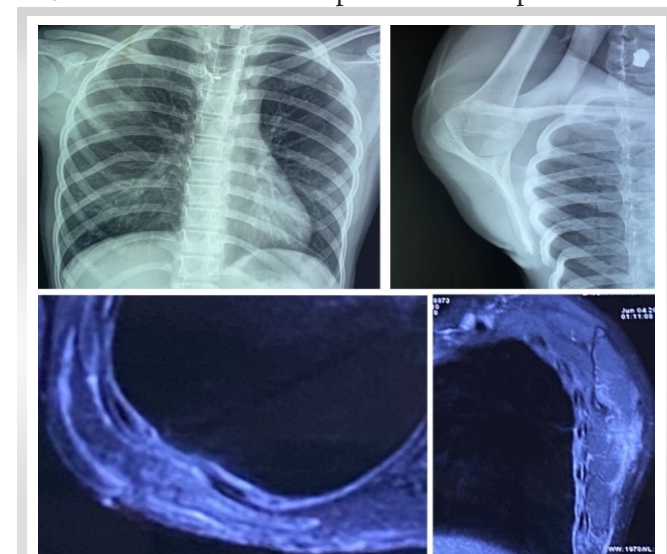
Post-operative X-ray and magnetic resonance imaging.
